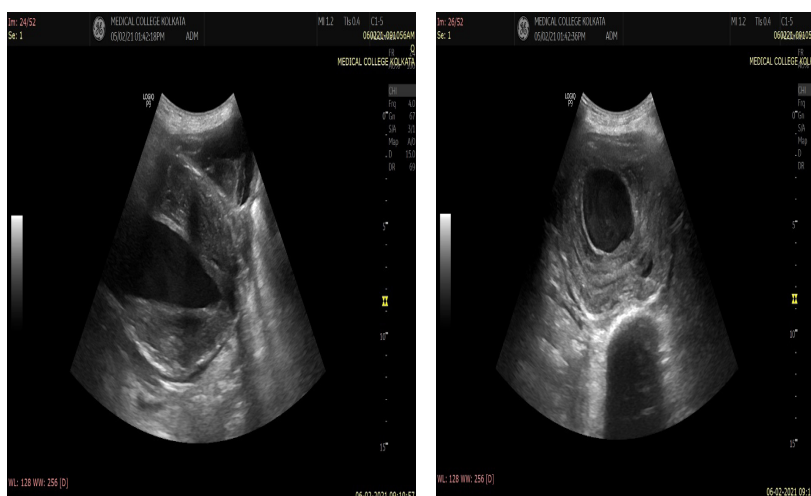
2D ultrasound in axial and longitudinal scan shows a infrarenal dilation of abdominal aorta with a concentric wall thrombus surrounding it with a partly echogenic fluid collection antero-lateral to it.
